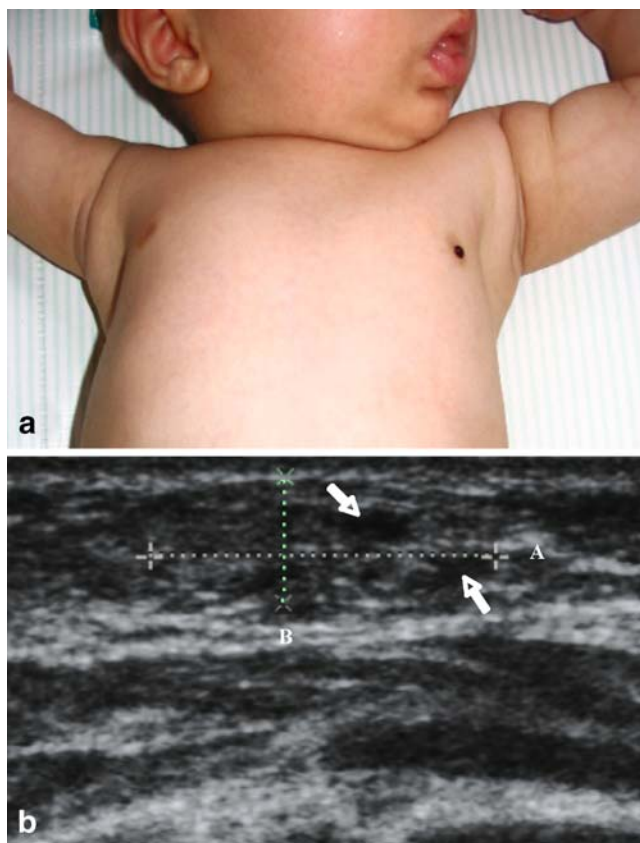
a. Unilateral bloody nipple discharge, b. Ultrasound of the left breast (A=11.9 mm, B=4.4 mm), ductal ectasia (arrows)
